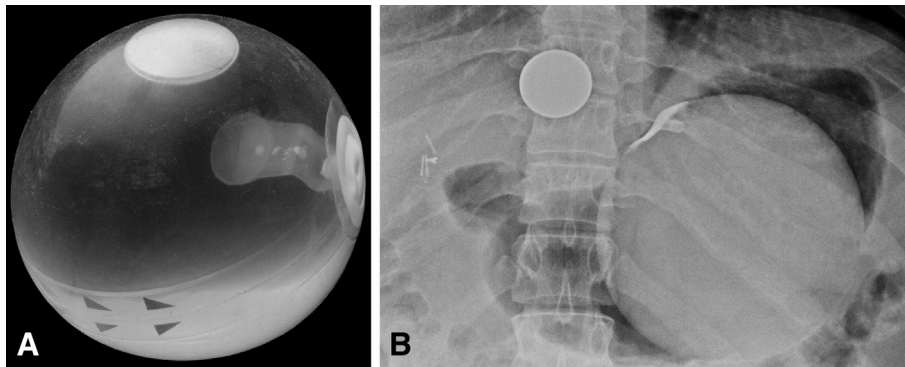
The Orbera Intragastric Balloon (formerly the Bioenterics Intragastric Balloon) (A) and abdominal radiograph of an Orbera balloon in situ (B). The balloon is made of a silicone elastomer and filled with 500 to 700 mL of saline solution. The valve is radiopaque, allowing the balloon to be visualized on radiography. In this radiograph, a coin is taped on the lower sternum to permit follow-up comparisons of balloon size.
